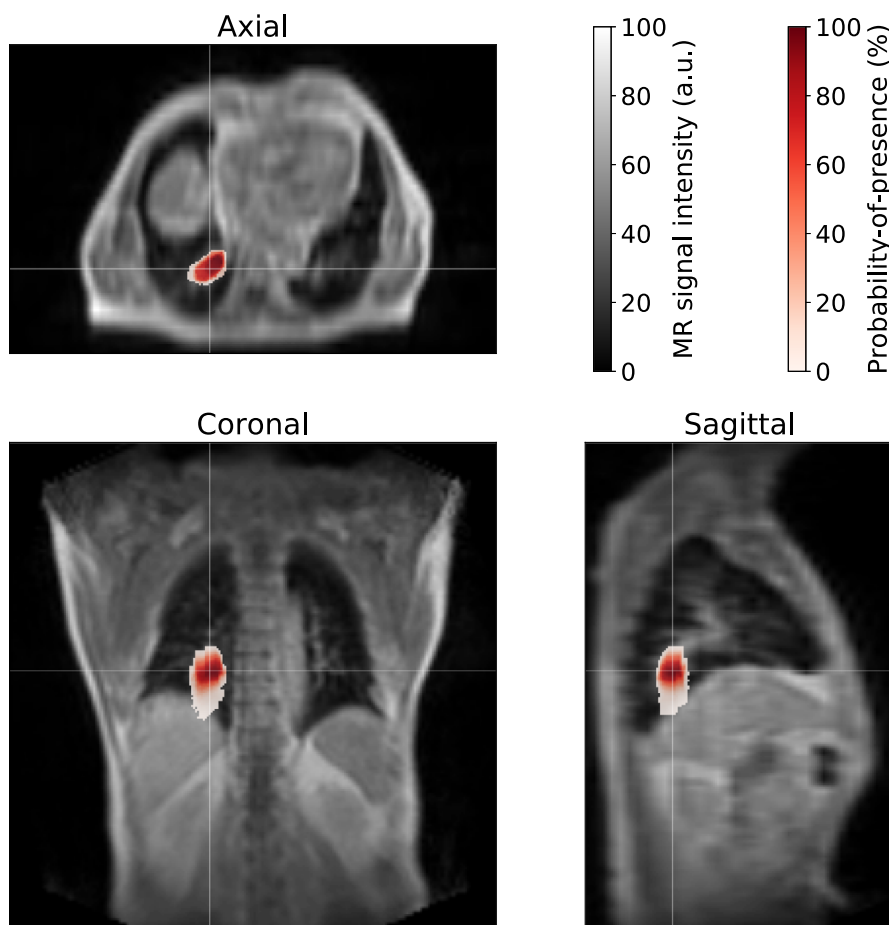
Three-dimensional probability-of-presence (POP) distribution. The POP is color-encoded and superimposed on four-dimensional-magnetic resonance imaging (MRI) ( $t'$ ) for the reference MRI session of Patient 2. The crosshairs indicate the slice positions in the respective axial, coronal, and sagittal views. [Color figure can be viewed at [wileyonlinelibrary.com](http://wileyonlinelibrary.com)]
